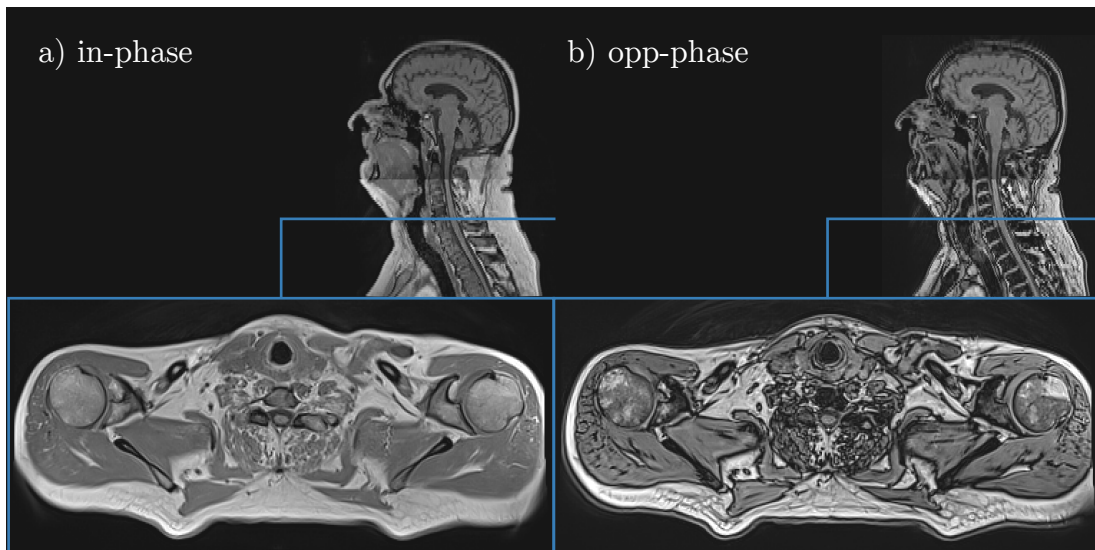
Resulting images from a Dixon sequence. a) in-phase image, b) opposed-phase image. A transverse slice and sagittal are displayed (the blue line indicates the position of the transverse slice). By adding or subtracting the images, the isolated water signal and lipid signal, respectively, can be calculated. The in-phase image shows a characteristic dark band around bones and is hence used in this thesis for bone identification in the MR image.
